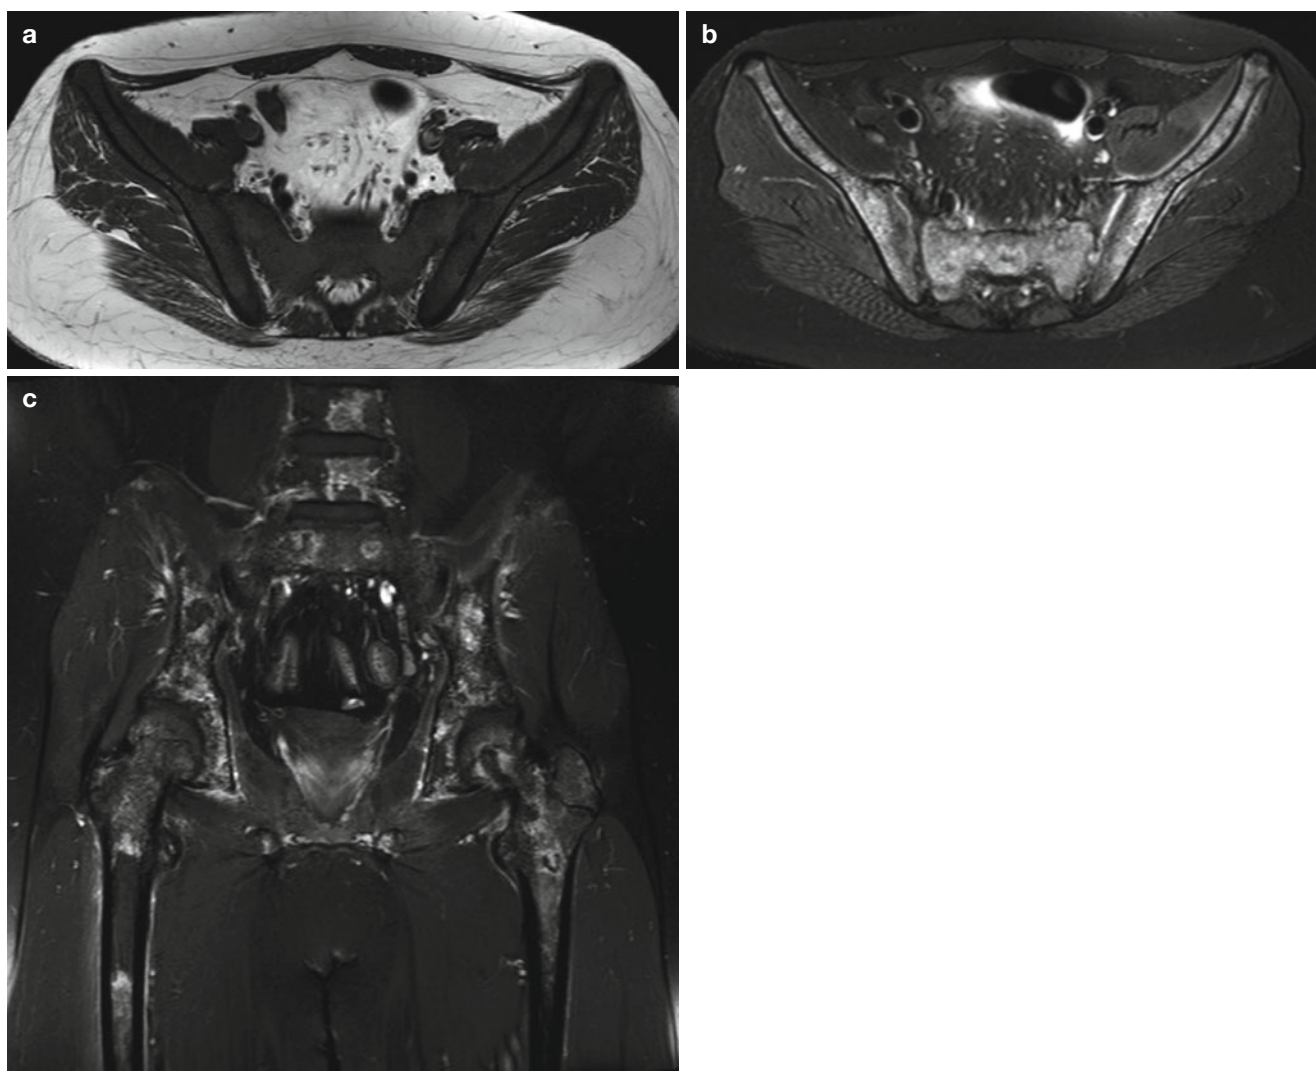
Plasmablastic lymphoma.* (a–c) T1-weighted axial (a), T2 STIR axial (b), and postcontrast fat-suppressed coronal (c) images show diffusely abnormal bone marrow with heterogeneous enhancement in the lower lumbar spine, sacrum, pelvic bones, and both proximal
